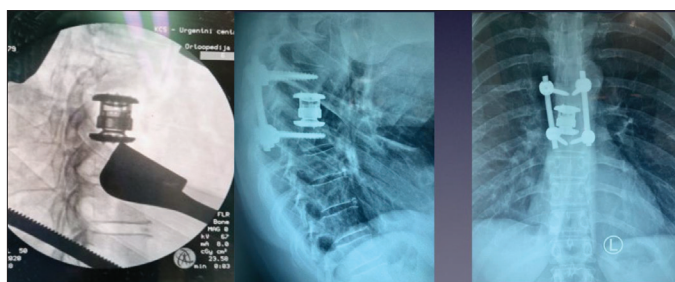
Postoperative findings: X-ray – anteroposterior and lateral view: properly positioned osteosynthesis material
